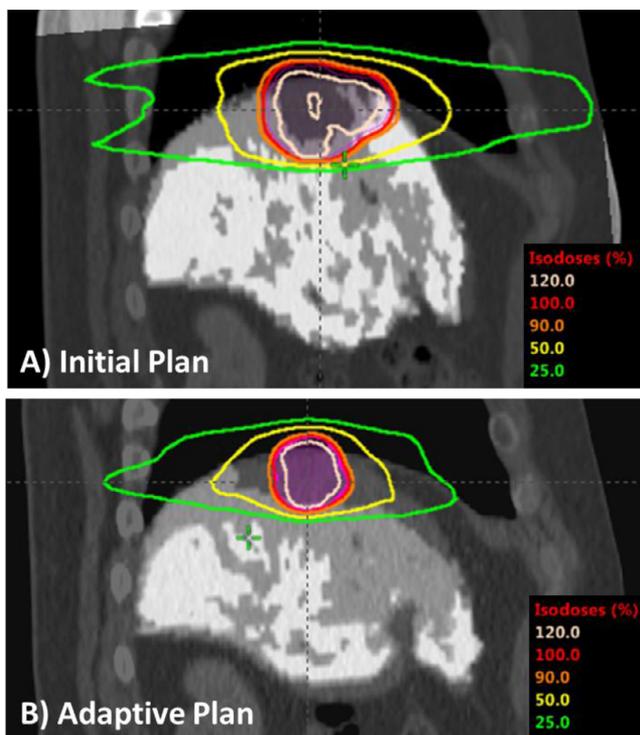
(A) Initial and (B) adaptive treatment plans for a patient on personalized adaptive trial for hepatocellular carcinoma. Functional liver information (thresholded functional maps from gadoxetic acid DCE-MRI) is used to guide plan optimization for both baseline and adaptive planning. Note that the target volume is also adapted.
